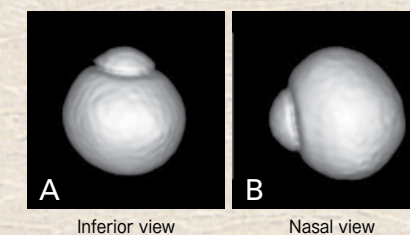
3D MRI images of a normal eye
